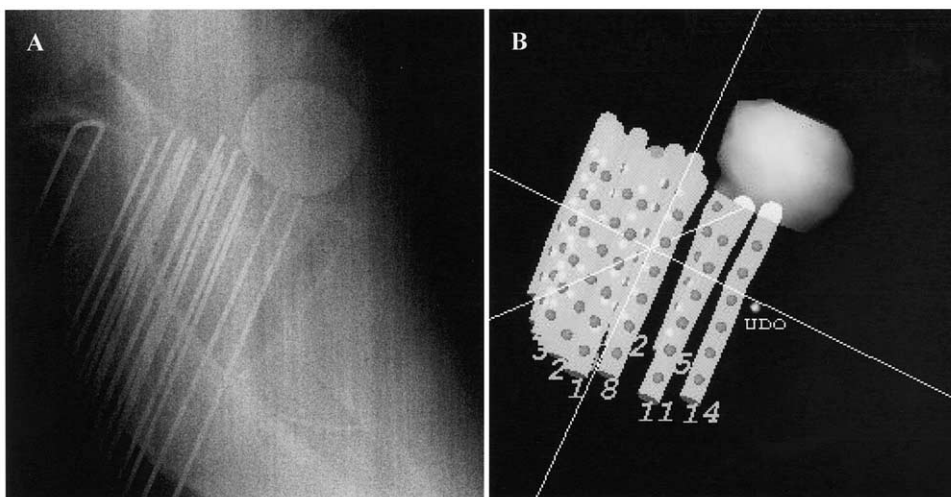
(a) Diagnostic portable X-ray showing relationship between Foley balloon and brachytherapy catheters acquired immediately before radiotherapy delivery and compared with (b) surface-rendered image generated from treatment planning MRI. No appreciable motion of catheters was noted.
